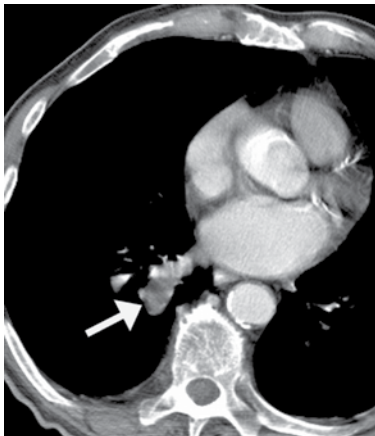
(b) - : Contrast enhanced CT scan post ablation showing an area of necrosis (arrows).
